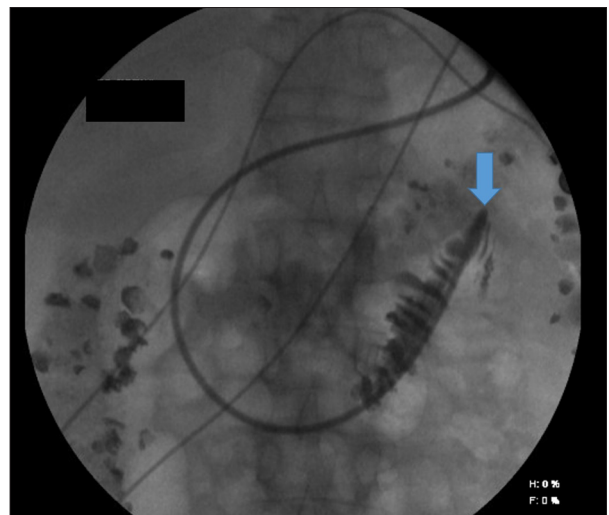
Abdominal x-ray after fluoroscopic guided Dobhoff tube placement. Small amount of contrast injected to confirm Dobhoff tube (see arrow) positioning in the fourth portion of the duodenum.
